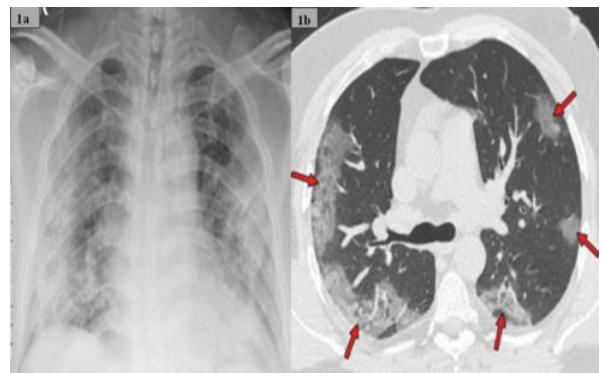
Antero posterior chest- radiograph shows multiple peripheral consolidation opacities in both lungs.(1a) Bilateral areas of ground-glass opacities(arrows) in a peripheral distribution.(1b)
